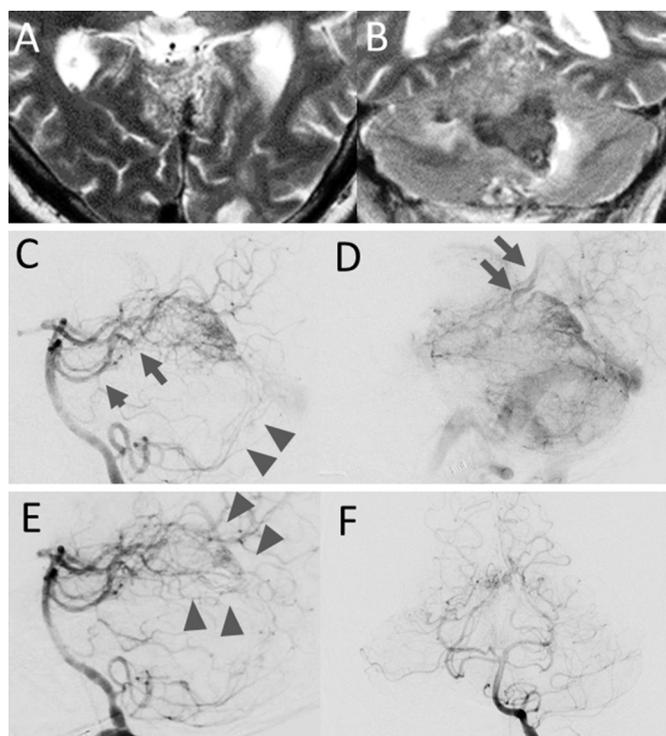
(A) Axial and (B) coronal magnetic resonance images show abnormal vasculatures indicating arteriovenous malformation in the superior vermis in addition to intracerebellar hemorrhage. (C) Arterial and (D) venous phases of vertebral angiographies show the arteriovenous malformation (AVM). The main feeders of the AVM are the bilateral superior cerebellar arteries (arrows) and posterior inferior cerebellar arteries (arrow heads). The draining vein from the AVM is the superior vermian vein (D, arrows). (E) Lateral and (F) coronal view of vertebral angiographies after endovascular embolization demonstrate flow reduction of the posterior part of the nidus (arrows).
